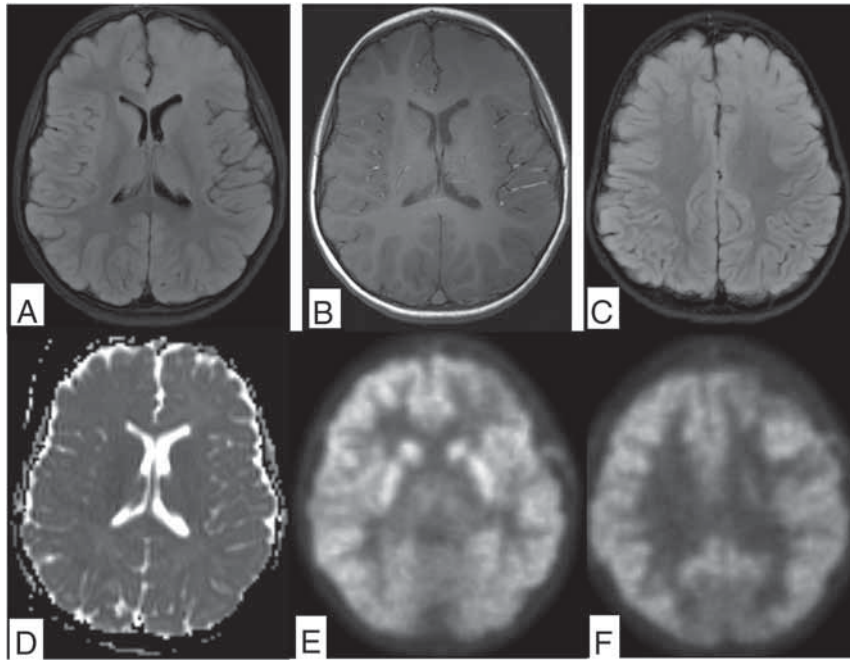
Diffuse astrocytoma in 4-year-old child demonstrates a nonenhancing FLAIR hyperintense mass involving the gray and white matter of the left frontal lobe (A and B). There is no evidence of reduced diffusion or hypointense signal on ADC (C and D). The inferior aspect of the lesion demonstrates a subtle decrease in FDG uptake compared with the contralateral side (E), while the superior portion demonstrates relative hypermetabolism on FDG-PET (F).
